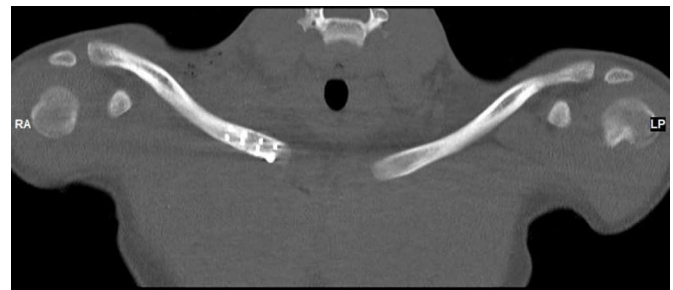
Post-operative CT scan coronal, the grind locking plate is stabilizing the fracture
